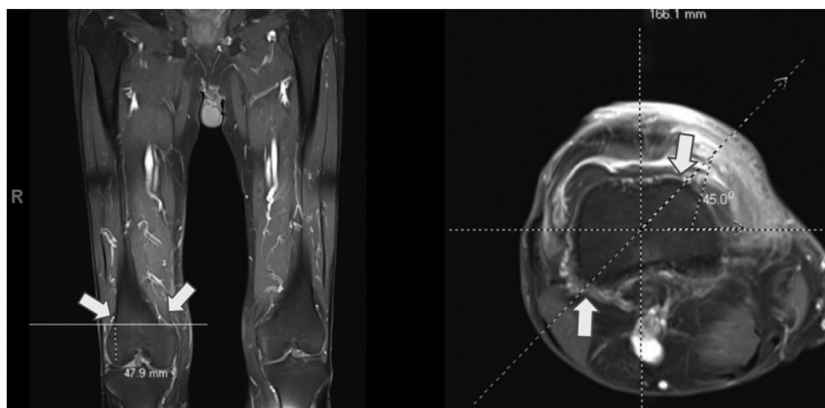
Coronal MRI of right femur with corresponding scout mode axial MRI at most distal zone (1A) with geniculate arteries labeled (white arrows) and projected femoral pin at 45°. MRI, magnetic resonance imaging.
